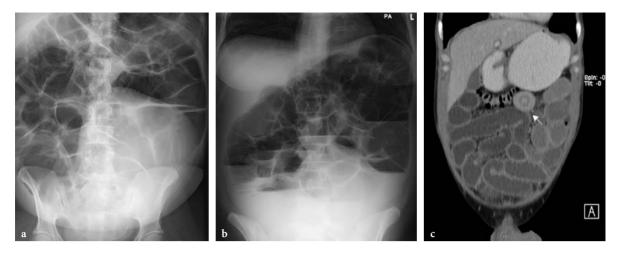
a,b Paralytic ileus. Note the extremely dilated small bowel loops and also the colonic loops containing gas and fluid levels. c CT image shows multiple dilated loops of almost equal caliber: indicative of paralytic ileus. *Arrow* indicates small bowel intussusception
